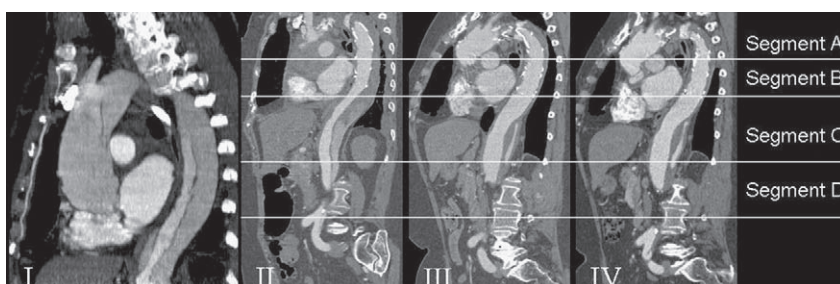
Aortic segments for the evaluation of the true and false lumen are shown in panels I to IV. (I) A 65-year-old woman underwent proximal aortic replacement and antegrade stent grafting of the descending aorta for acute type A AD. Computed tomography (II) postoperatively, (III) after 6 months, and (IV) 24 months demonstrated durable exclusion of the false lumen in the stent grafted aortic portion. The volume of the true lumen increased and the volume of the false lumen decreased.
